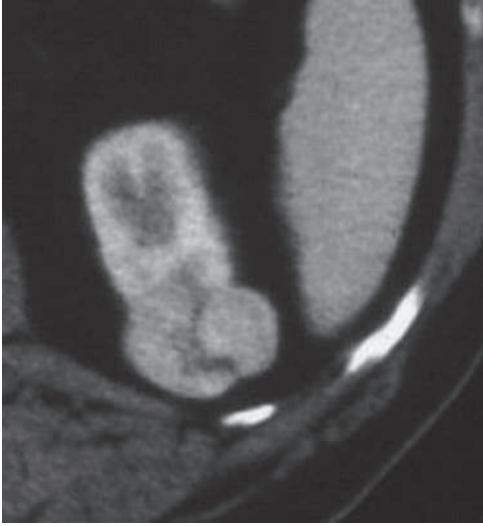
Coronal reformatted views of a contrast-enhanced CT study approximately 3 years following radiofrequency ablation of a lower pole renal tumor. A thin "halo" is seen within the perinephric fat at the treatment site (arrow).
